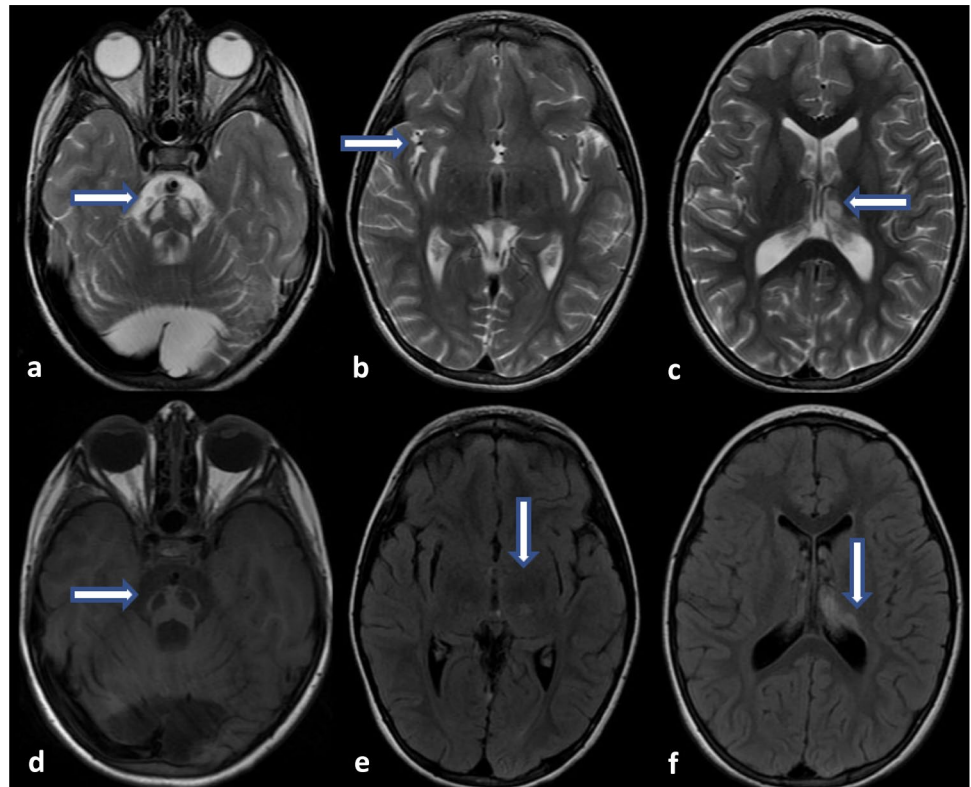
MRI findings in the 2nd attack of patient 5. There is extensive involvement in the pons and bilateral thalamus, also a cystic appearance on the pons
